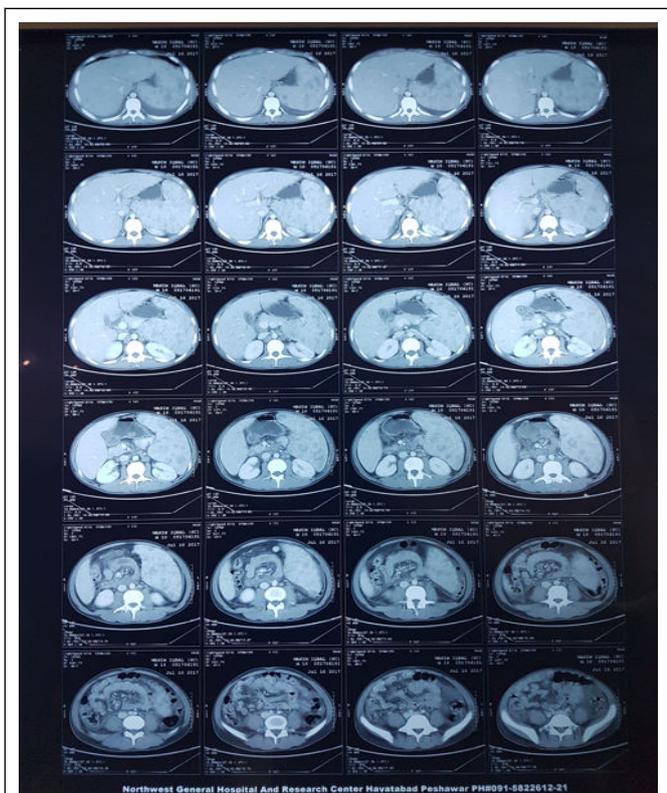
CT Abdomen showing splenomegaly, multiple collections in left subphrenic, subhepatic, splenic subcapsular and paracolic gutter.
